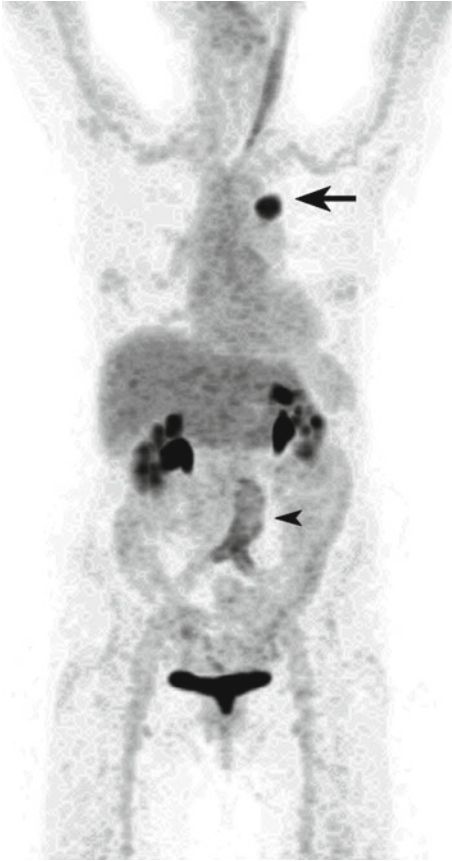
Maximum intensity projection (MIP) image of an 80-year-old woman who underwent a FDG PET scan to stage newly diagnosed lung cancer in the apical segment of the left lower lobe. The primary demonstrated intense FDG uptake with a SUV_{max} of 17 (*arrow*), and PET did not reveal metastatic disease. There was also mild diffuse linear-increased FDG accumulation surrounding the asymptomatic aortobifemoral vascular graft (*arrowhead*). There was prominent muscle activation along the left sternocleidomastoid muscle as well as physiologic tracer excretion in both kidneys and bladder. The patient subsequently underwent surgery with a curative intent, and a T2aN0 moderately differentiated adenocarcinoma was resected which was confined to the lung parenchyma
